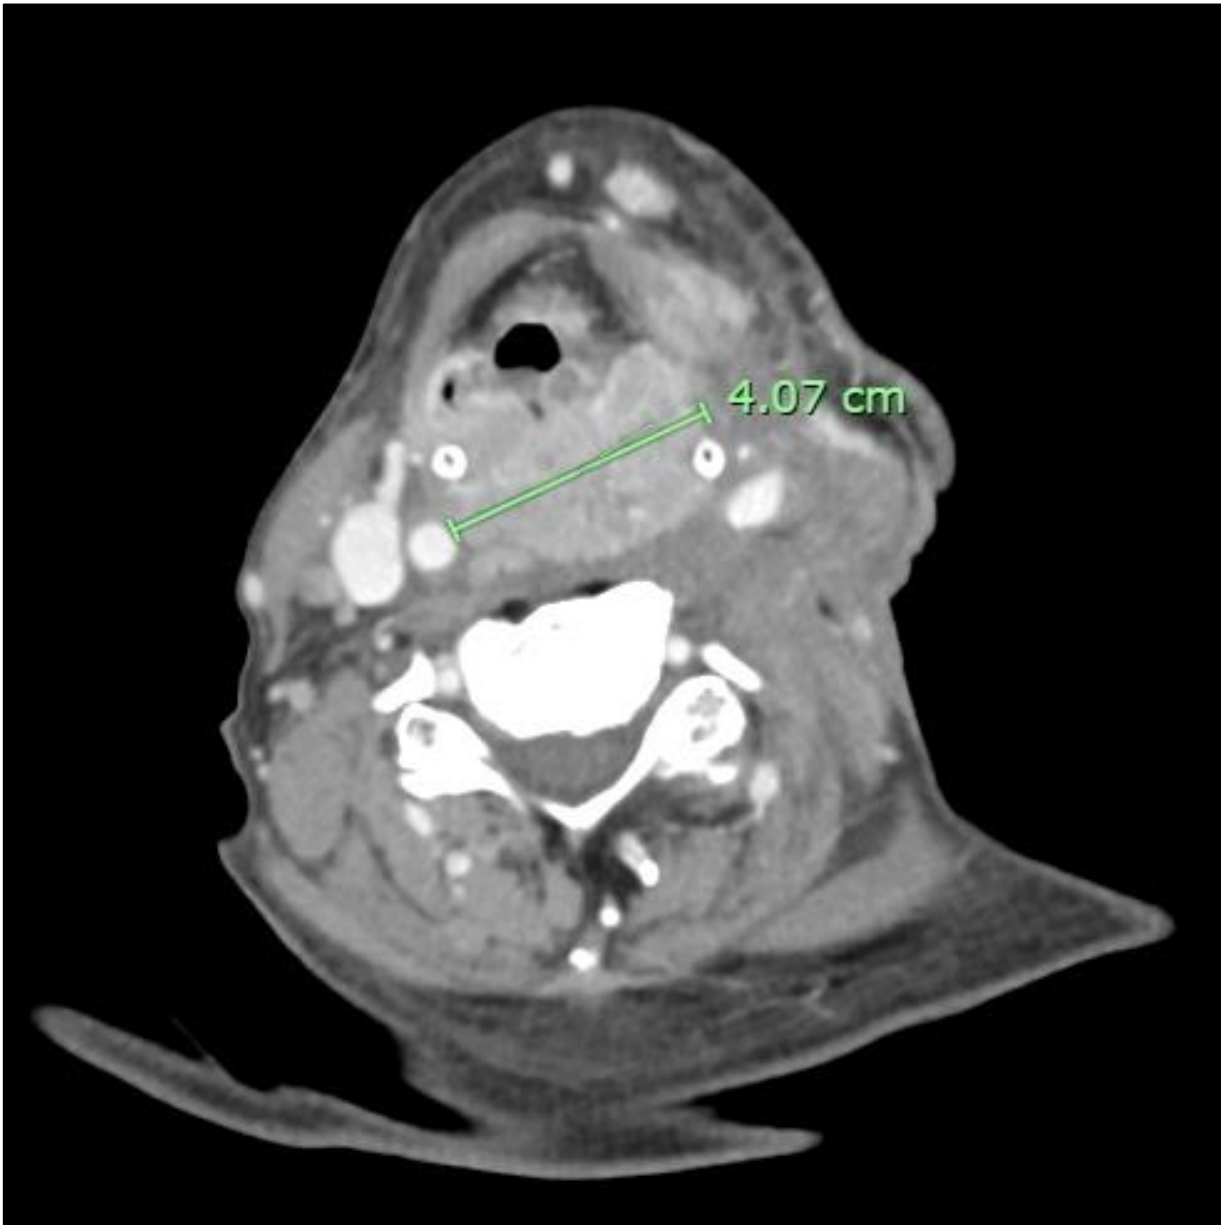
Axial CT showing 4.1 cm recurrent tonsillar lesion
